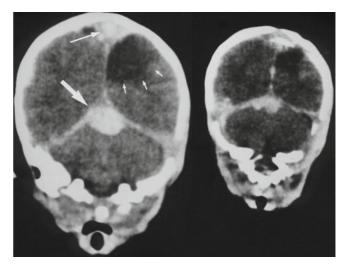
Coronal CT sections in a term infant with sinus thrombosis (*left*) due to impressed occipital squame (*right*). Also observe tentorial subdural hematoma (*large arrow*) and area of ischemia on the left convexity (*small arrows*)
